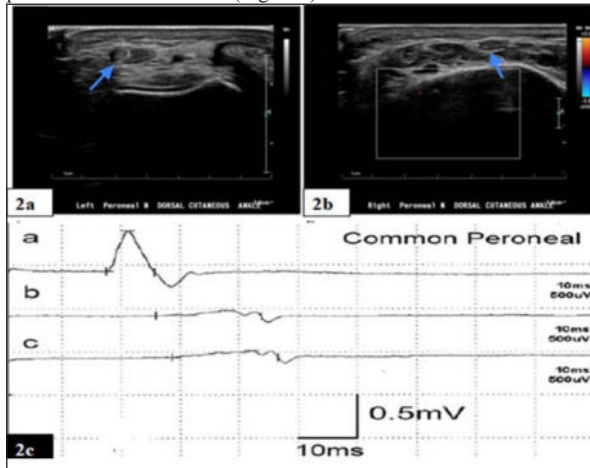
Ultrasound of left common peroneal nerve done revealed thickening of the nerve and faciae (arrows) at the fibular head.(2a,b) Decreased motor conduction in peroneal nerve across fibular head(2c)
